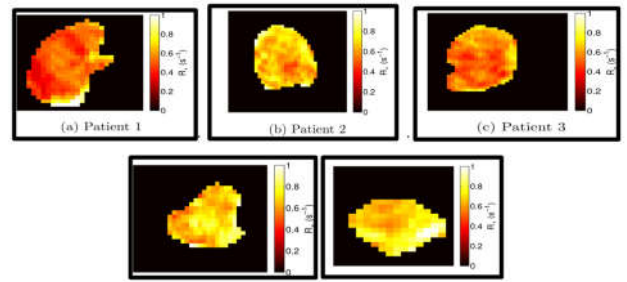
MRI maps for a single slice for all 5 patients
